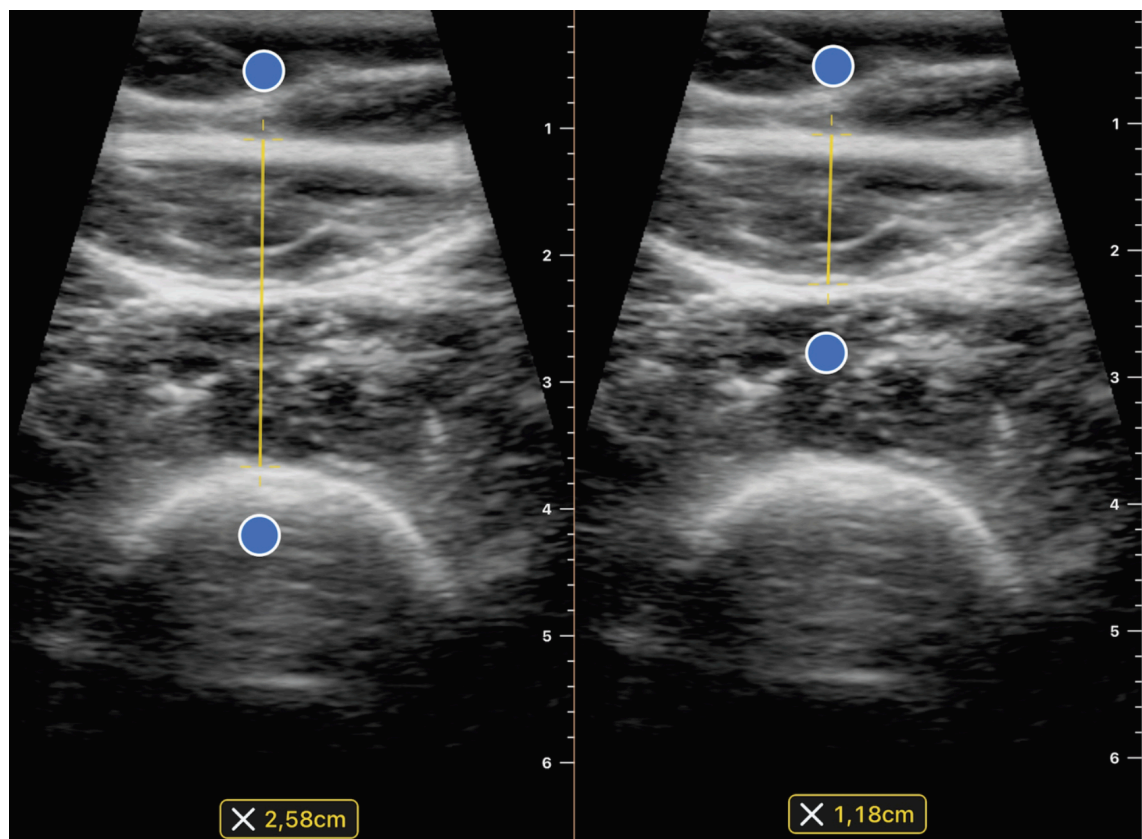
Ultrasound measurements of quadriceps femoris (left) and rectus femoris (right); Yellow line represent the measurement of muscle thickness.
